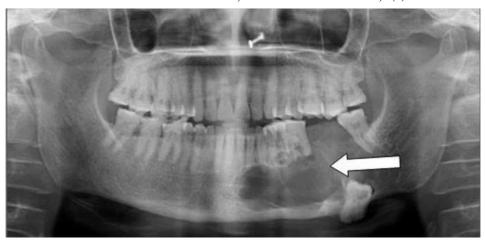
Orthopantomograph (OPG) showing a multilocular radiolucency with displaced unerupted second molar (white arrow)
